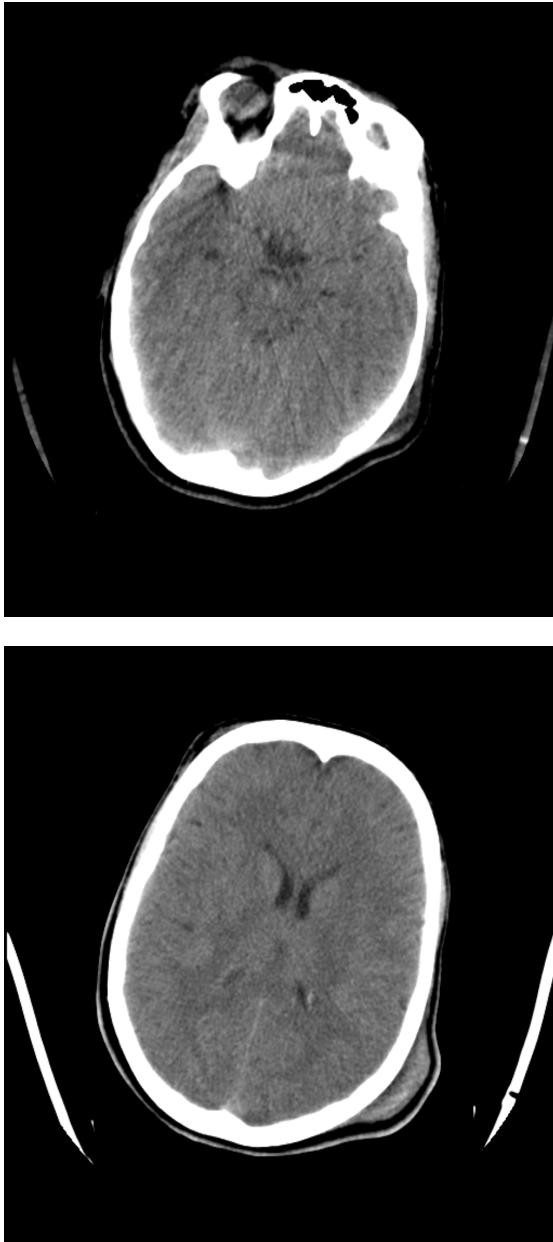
Initial CT - millimetric lesions in the antero-lateral mezencefalic region, right temporal lobe and in the left occipital horn
